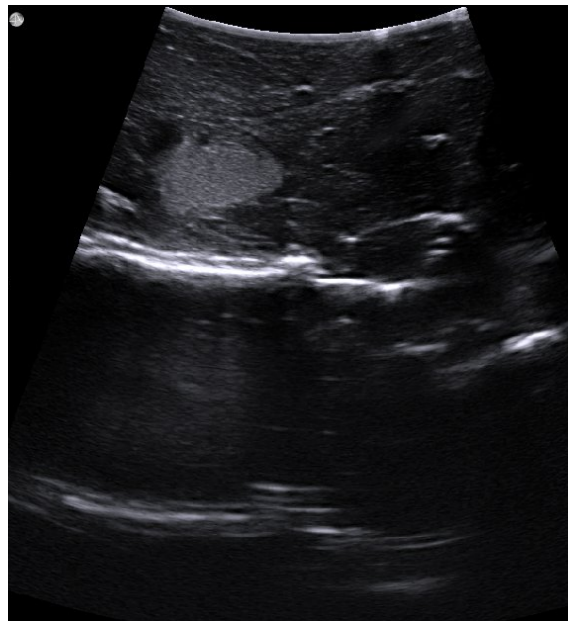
Cropped ultrasound image.
